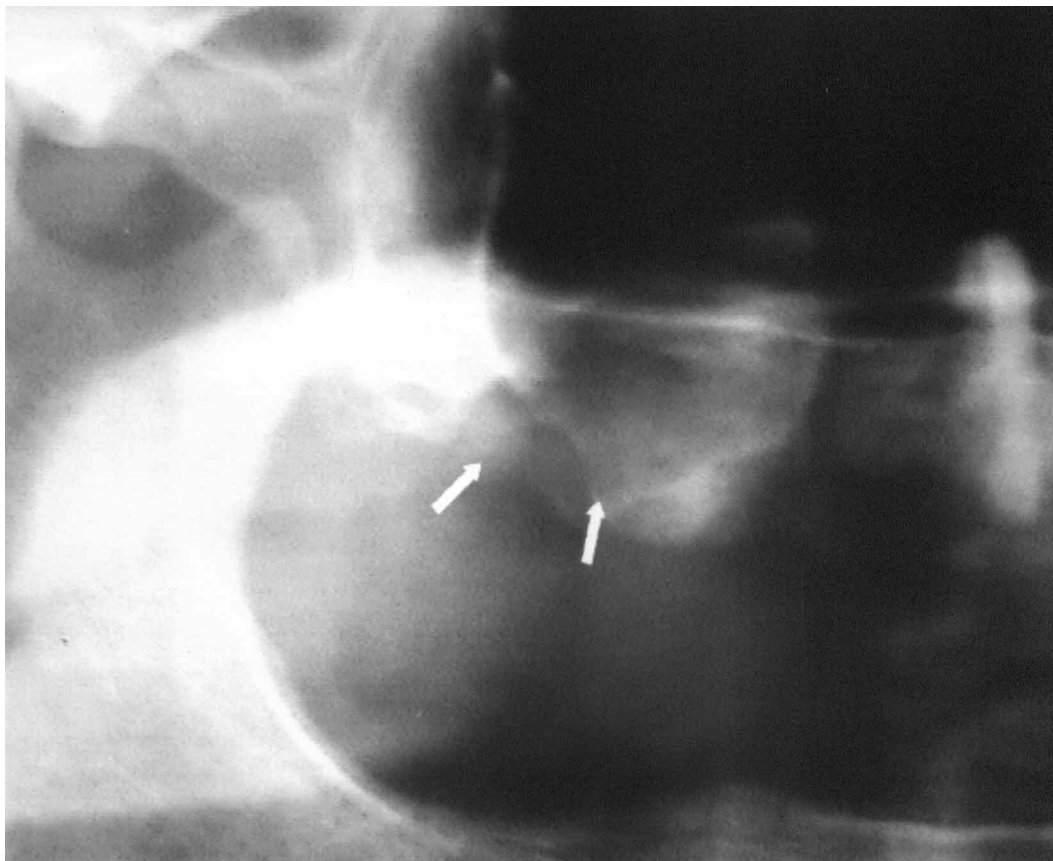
Panoramic radiograph immediately before surgical procedure. Arrows indicate the oroantral communication site.
